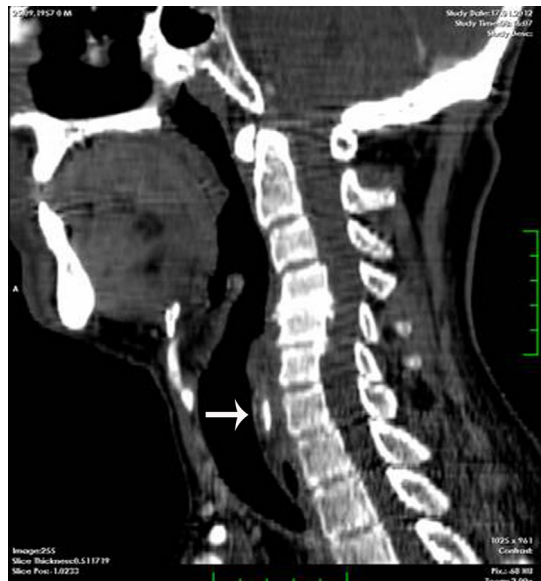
Sagittal reconstructed CT scan showing the elongation of cricoid osteophyte caudally (white arrow).
